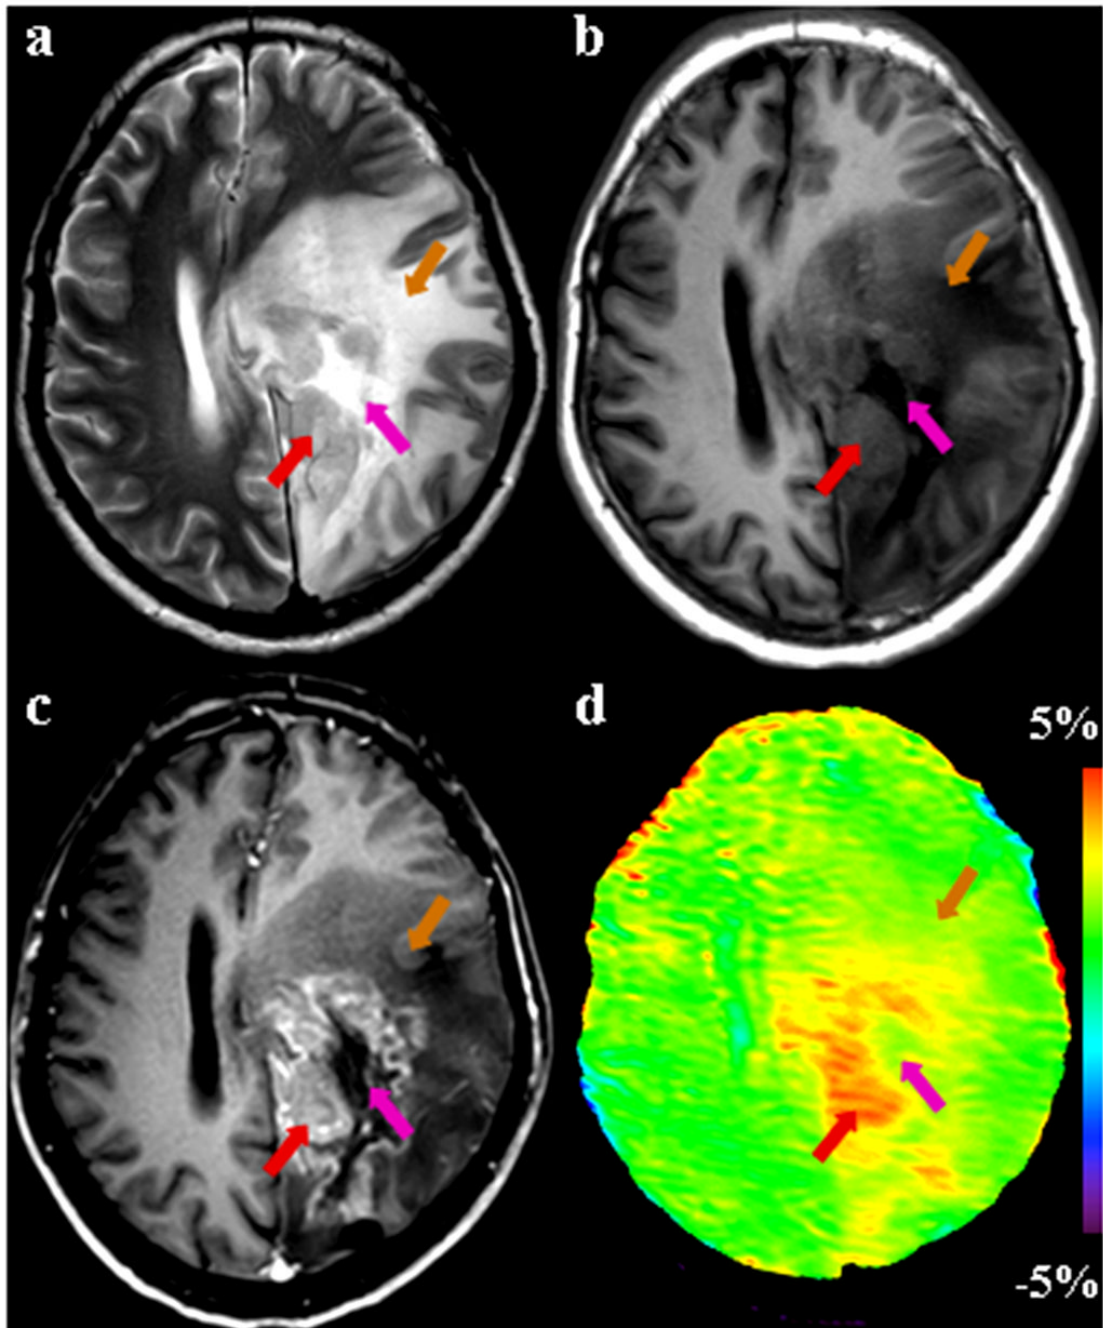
MR images from a patient with recurrent astrocytoma (grade III), acquired four months after treatment. (a) T2-weighted image shows the recurrence of glioma with heterogeneous hyperintensity in the left parietal lobe. (b) T1-weighted image shows a heterogeneously hypointense lesion. The exact location of the tumor core is not clear. (c) Post-contrast T1-weighted image reveals a gadolinium-enhancing tumor core (red arrow) and a necrotic area (pink arrow). The recurrent tumor is associated with the surrounding edema and mass effect. (d) APT image shows that there is a clear increase in APT signal intensity in the tumor core, identified by the gadolinium-enhanced T1-weighted image. The regions of necrosis (pink arrow) and edema (orange arrow) are almost isointense on APT.
